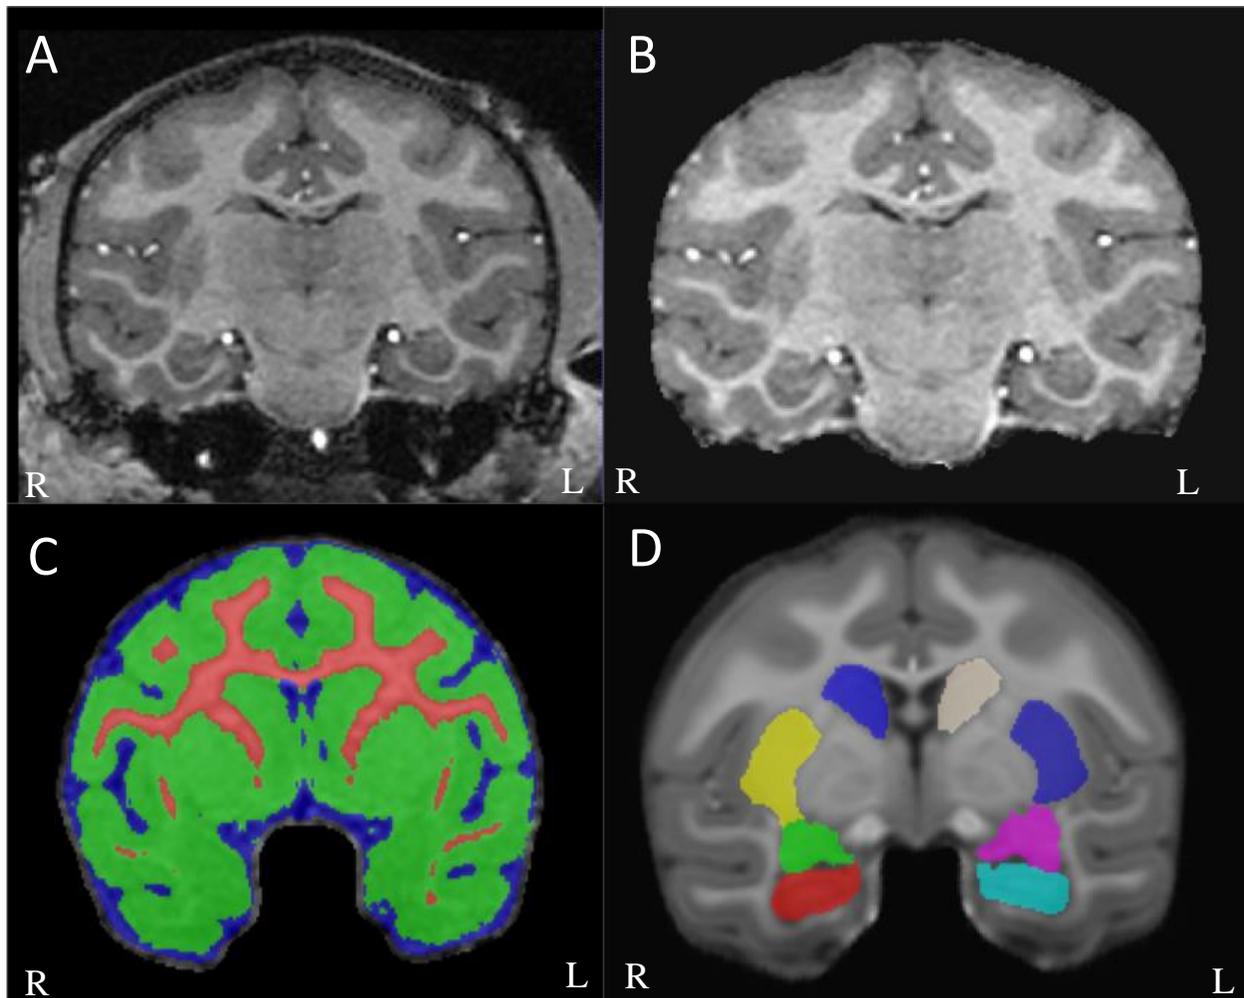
Representative images of skull-stripping, automatic tissue segmentation and subcortical ROI parcellation generated from AutoSeg. A) Coronal view of the brain in a T1-MRI non-skull stripped image. B) The T1 image as A, but skull-stripped. C) Coronal view of the brain, segmented into white matter (red), gray matter (green), and CSF (blue). D) Coronal view of subcortical parcellations: right hippocampus (red), right amygdala (green), right putamen (yellow), right caudate (dark blue), left caudate (beige), left putamen (violet), left amygdala (pink), and left hippocampus (light blue).
